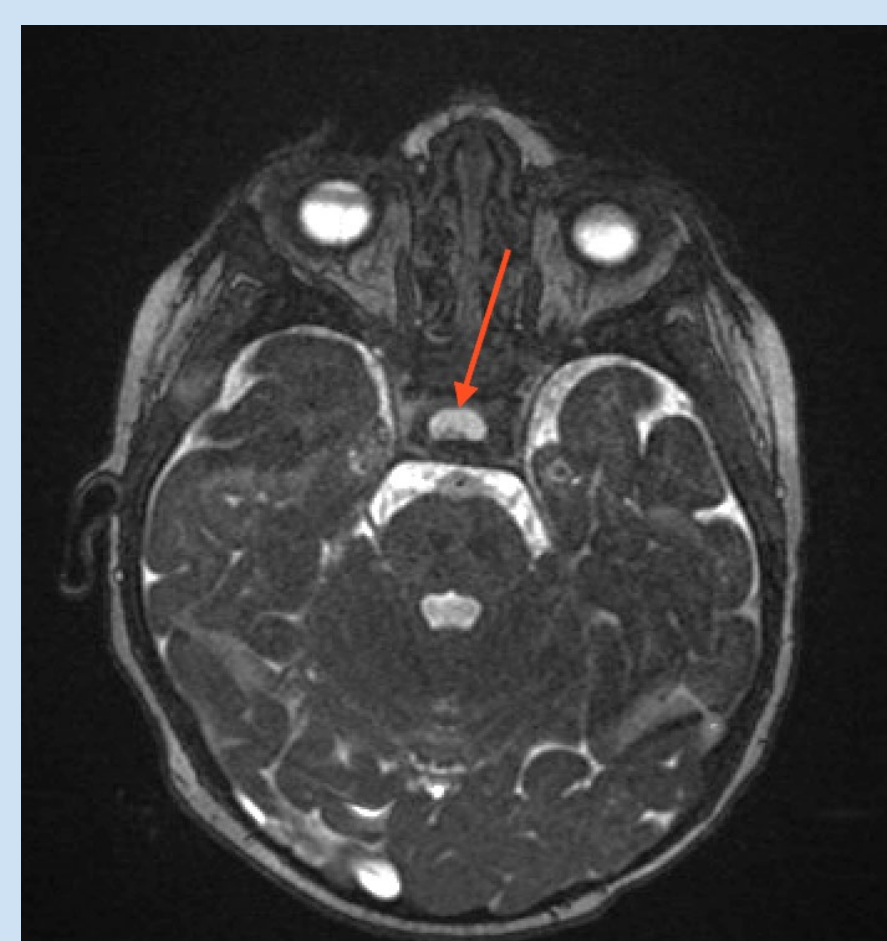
Case 6, intrasellar Rathke cleft cyst (MRI).
